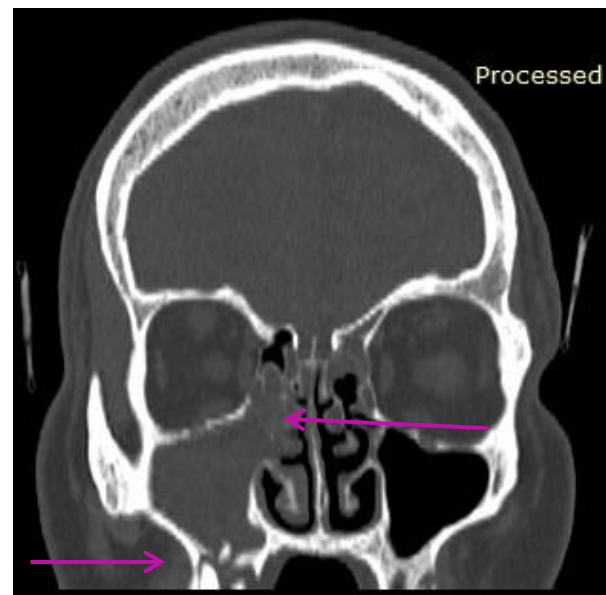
Coronal CT Scan. Bone window Osteolysis of the floor and medial wall of the right maxilar sinus, acute maxilar sinusitis (pink arrow).
